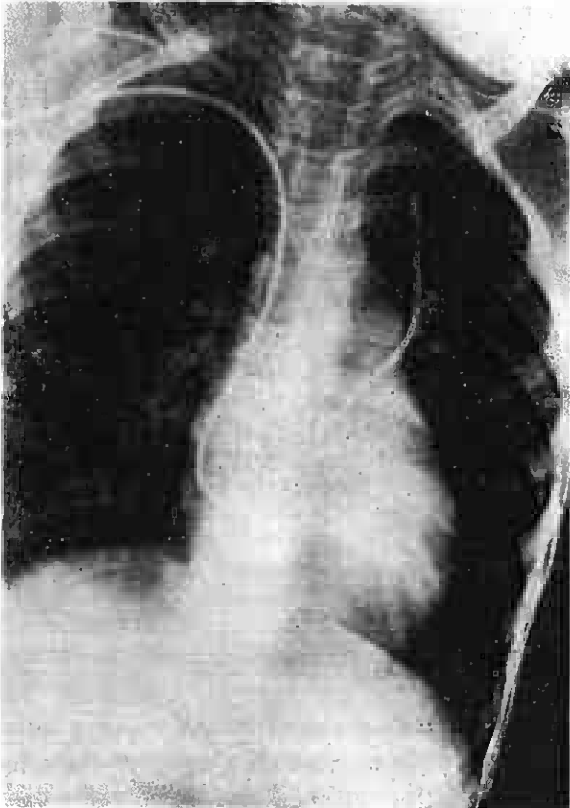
X-ray chest in a case of Atrial Septal defect showing the catheter tip in the left Pulmonary Vein through the septal defect.
